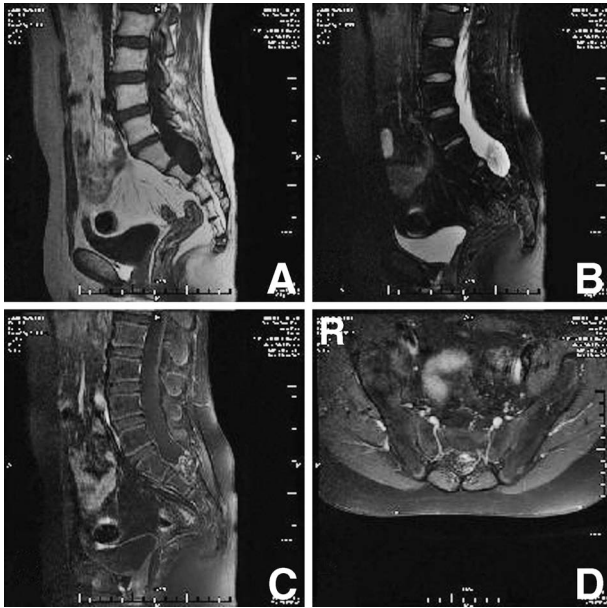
Magnetic resonance images showing the lesion as slightly hypointense on the T₁-weighted image (A), and slightly hyperintense on the T₂-weighted image (B) at the S2 level, and obvious homogeneous enhancement with contrast medium on sagittal (C) and transaxial (D) T₁-weighted images.
